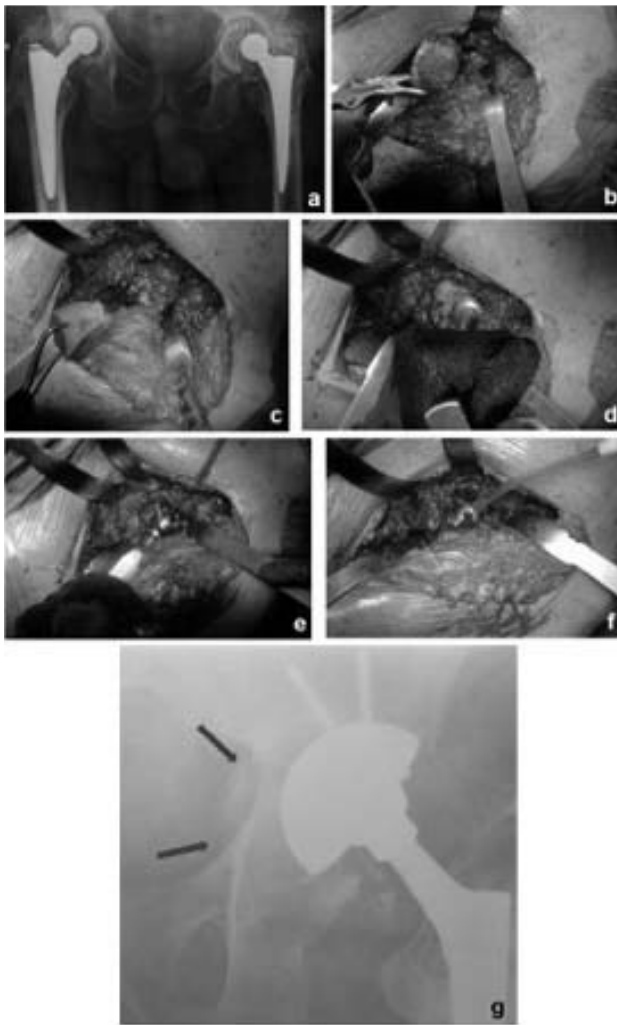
a): Preoperative radiograph of an isolate cup mobilization in a Paprosky grade 3B acetabular bone loss; b): The surgery was performed through a proximally extended DA approach; c, d): Medial bone stock deficiency was repaired with omologous bulk bone graft; e, f): Good implant stability was achieved with a standard porous hemispheric cup and 2 cancellous bone screws; g): postoperative radiographs showing the good implant osseointegration at 28-month follow up. The proximally extended DA approach allowed an easy acetabular bone stock reconstruction and a good implant positioning.*
